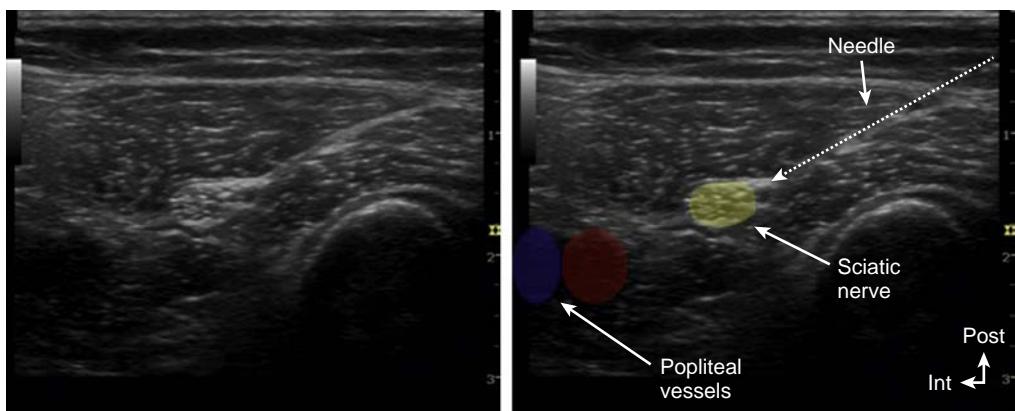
Ultrasound of sciatic popliteal nerve block. Sciatic nerve is usually located laterally and superficially to the popliteal vessels.
